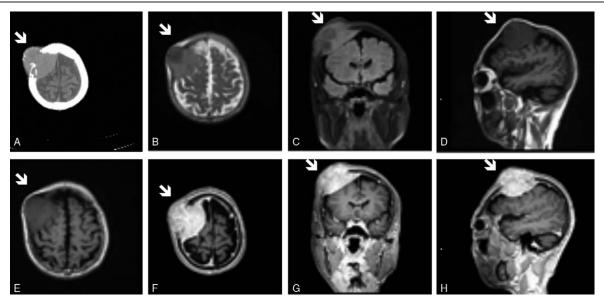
(A) CT showed a large epidural mass with isointensity to the brain. The skull at the mass was destroyed and became osteolytic. (B-H) Cranial MRI showed a half of the right frontal mass was in the cranial, and the remaining was outside the skull with skull involvement. There was an obvious mass effect on the adjacent brain. On T1-weighted and T2-weighted MR images, the mass showed isointensity to the brain, and homogeneous enhancement after Gd-DTPA injection.
